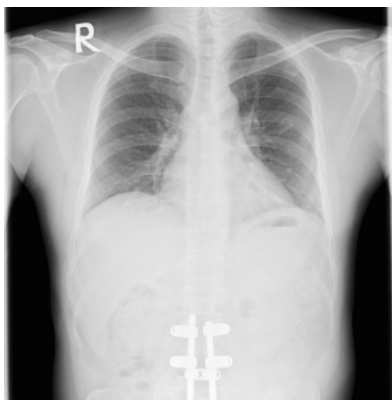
The chest X-ray showed internal fixation internal rods and screws fixations for L4 and L5. Pulmonary fields was unremarkable
